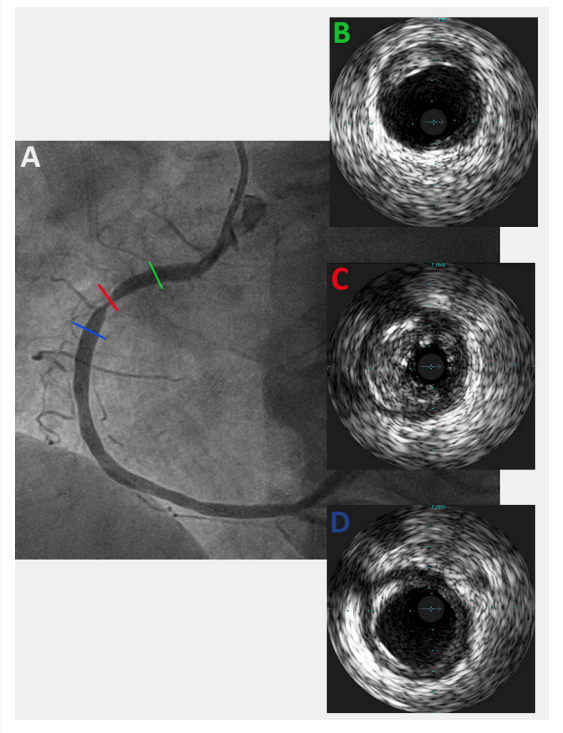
(A) Eight-month right coronary artery angiogram. (B) Cross-sectional intravascular ultrasound image (IVUS) at the level of the green line. (C) Cross-sectional IVUS at the level of the red line, showing the late stent recoil in the absence of neo-intimal proliferation. (D) cross-sectional IVUS at the level of the blue line.
